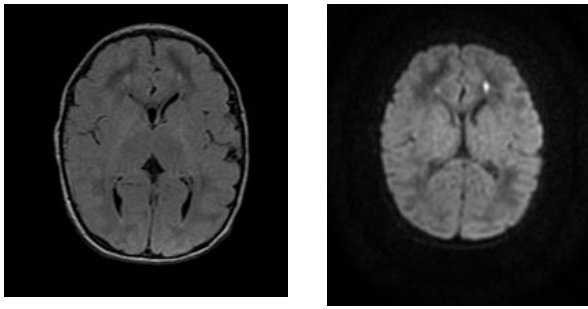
Magnetic resonance imaging (MRI) of the brain showing features suggestive of hypoxic-ischemic encephalopathy grade II with bilateral periventricular diffuse restriction.
